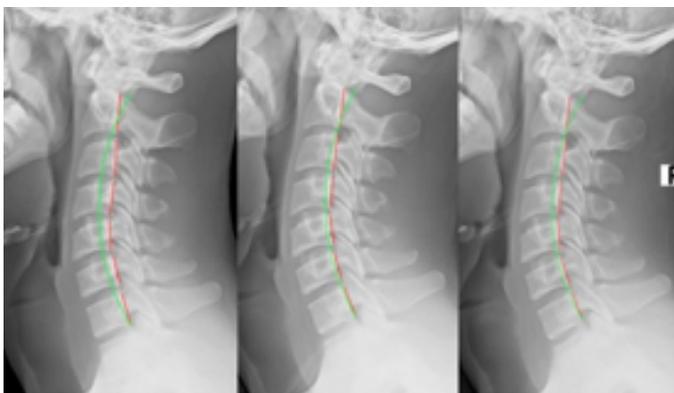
Lateral cervical radiographs. Left: Initial (1/3/18) image showing forward head translation and hypolordosis; Middle: Post-treatment (3/7/18) showing reduction in forward head translation and increase in cervical curve; Right: Follow-up (7/16/18) showing maintenance of structural improvements.
